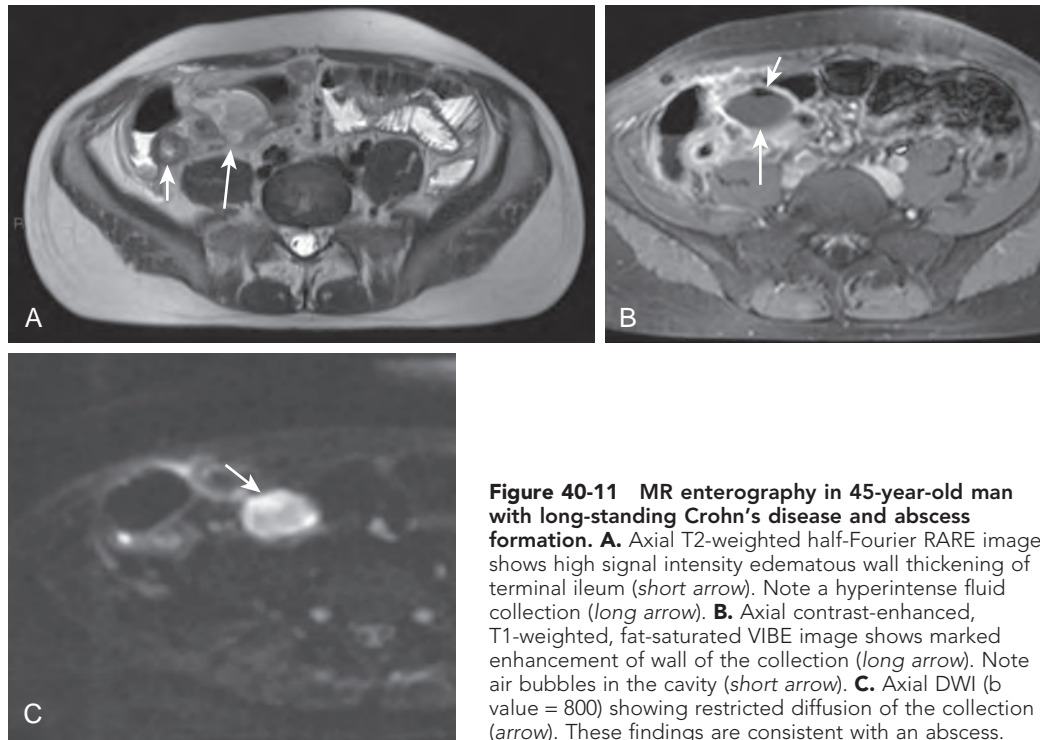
MR enterography in 45-year-old man with long-standing Crohn's disease and abscess formation. A. Axial T2-weighted half-Fourier RARE image shows high signal intensity edematous wall thickening of terminal ileum (*short arrow*). Note a hyperintense fluid collection (*long arrow*). B. Axial contrast-enhanced, T1-weighted, fat-saturated VIBE image shows marked enhancement of wall of the collection (*long arrow*). Note air bubbles in the cavity (*short arrow*). C. Axial DWI (b value = 800) showing restricted diffusion of the collection (*arrow*). These findings are consistent with an abscess.
